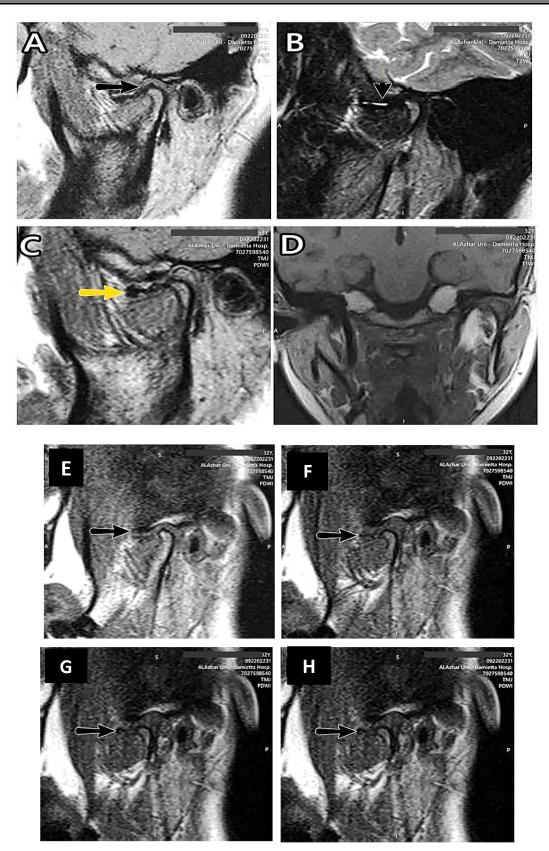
A 32-year-old female patient presented clinically by temporomandibular joint pain and locked jaw in open position on the left side. Static MRI [A-D images]: sagittal PDWI and T2WI MRI of left TMJ in closed [A, B] and open [C] mouth position and coronal T1 revealed anteriorly displaced deformed disc [flattened] seen in closed-mouth position with no reduction in open mouth position [yellow arrow] [C], associated with joint effusion [arrow head] [B] and thickening of retrodiscal tissue "pseudo disc" [black arrow] [A]. No sideway displacement is noticed in coronal T1WI [D]. Dynamic MRI [E-H images]: dynamic MRI study of left TMJ revealed anteriorly displaced disc in relation to condylar head without reduction on opening of the mouth associated with limited condylar translation. Diagnosis: A case of left anterior disc displacement without reduction [ADDWNR]
